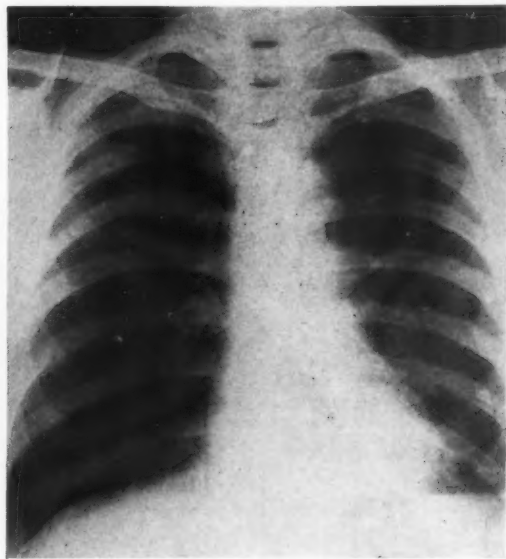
Radiograph of lungs of steel fettler for 30 years (aged 61). Generalised nodulation with beginning coalescence in right upper lateral zone.
